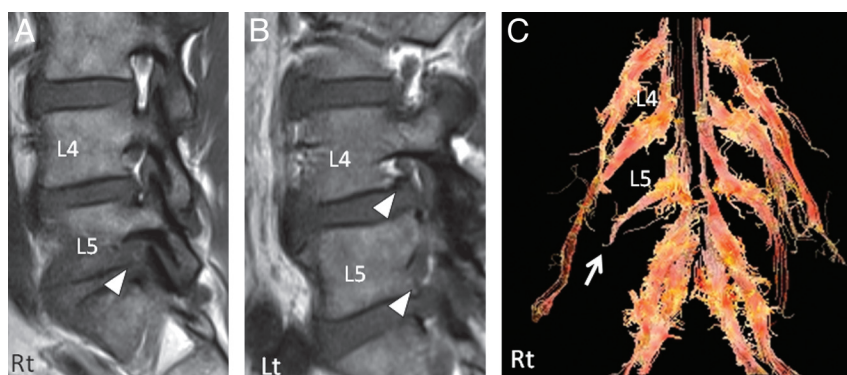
Sagittal T1-weighted MR images (A; right side, B; left side) and a diffusion tensor image (C) of a 62-year-old man with right L5–S1 foraminal stenosis (referenced as patient 4 in Table 3). Although asymptomatic foraminal stenosis on the left L4 and left L5 foramina (arrowheads in B) were found by MR imaging, abnormalities such as disruption of nerve fibers were only accurately detected at the symptomatic root by DTI (arrow in C).
